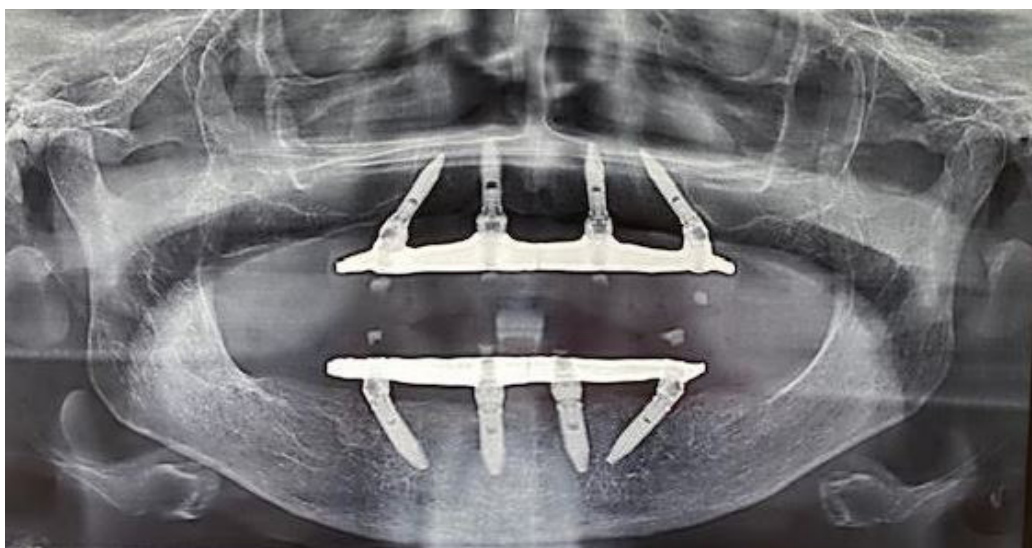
Final orthopantomography.*
